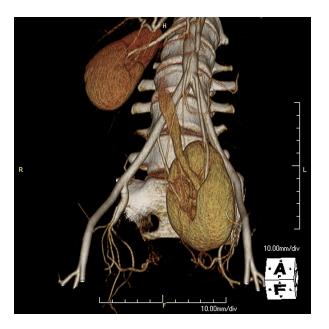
Computed tomographic scan shows the abnormal positioning of the left pelvic kidney, which did not contribute to the patient's diagnosis of loin pain hematuria syndrome.
